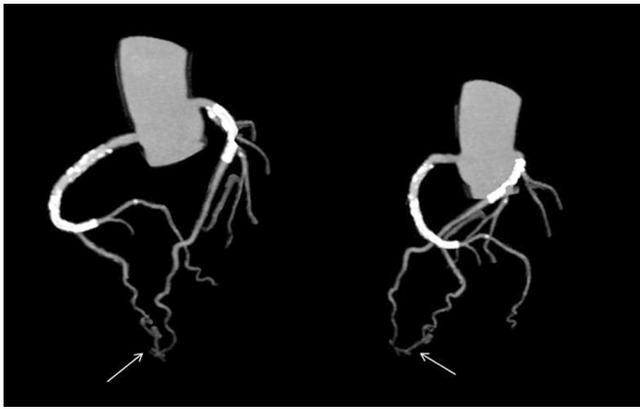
CT coronary angiography in left anterior oblique cranial view showing persistent intercoronary communication despite nonvisualization on conventional angiography.
